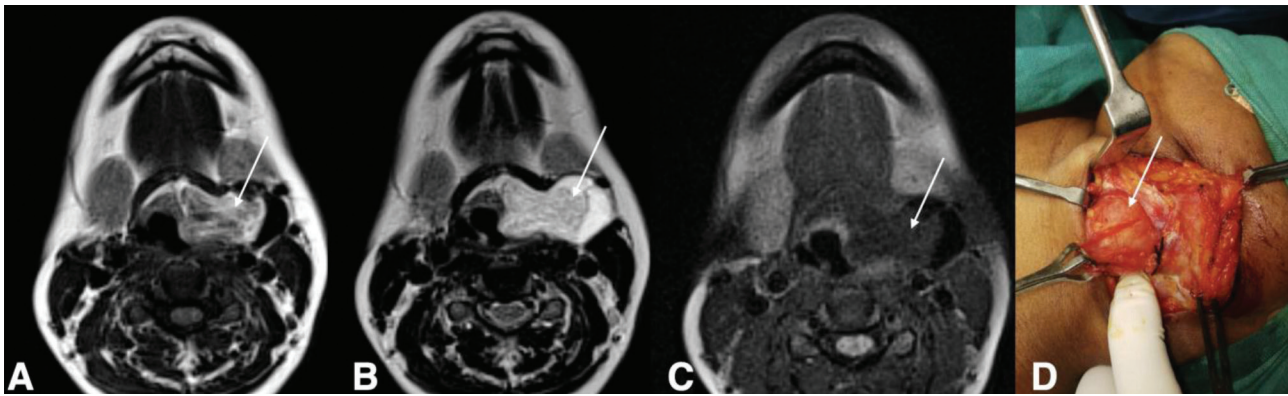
Axial contrast MRI images(A-T1, B- T2 and C-PDFS) shows a well defined heterogenous hyperintense lesion (white arrow)showing fat suppression on PDFS (C)noted in the left infra hyoid region in the left paraglottic space abutting the left vocal cord medially and submandibular gland laterally. Intraoperative photograph showing the lesion.
